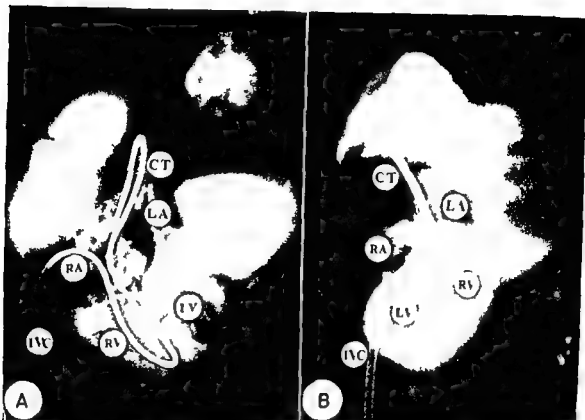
A* and *B* Radiologic postmortem studies with catheters placed in the cardiac cavities and the great arteries. Frontal views. The two pictures correspond to hearts with a common trunk. Identification of the ventricular chambers by means of the direction of the common trunk. *A* Common trunk in situs solitus with out ventricular inversion. *B* Common trunk in situs solitus with ventricular inversion. Notice that in both cases a single vessel arises from the heart. In Panel *A* the common trunk (CT) is directed from right to left indicating that the anatomically right ventricle (RV) is placed on the right. In Panel *B* the direction of the common trunk from left to right testifies to the fact that the anatomically right ventricle is placed on the left side. RA = anatomically right atrium. LA = anatomically left atrium. LV = anatomically left ventricle. IVC = inferior vena cava.
